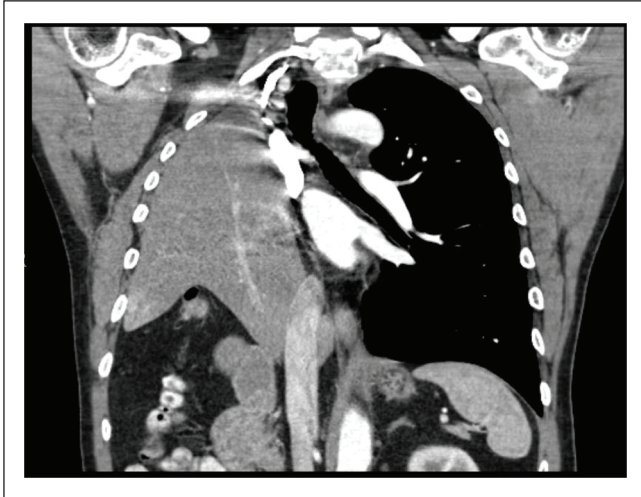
Preoperative CT scan noting significant compression of the right atrium and ventricle. Complete obliteration of the right intra-thoracic cavity can be noticed with the liver displaced into the apex of the thoracic cavity. The left main bronchus appears patent without signs of compression or stretching.
